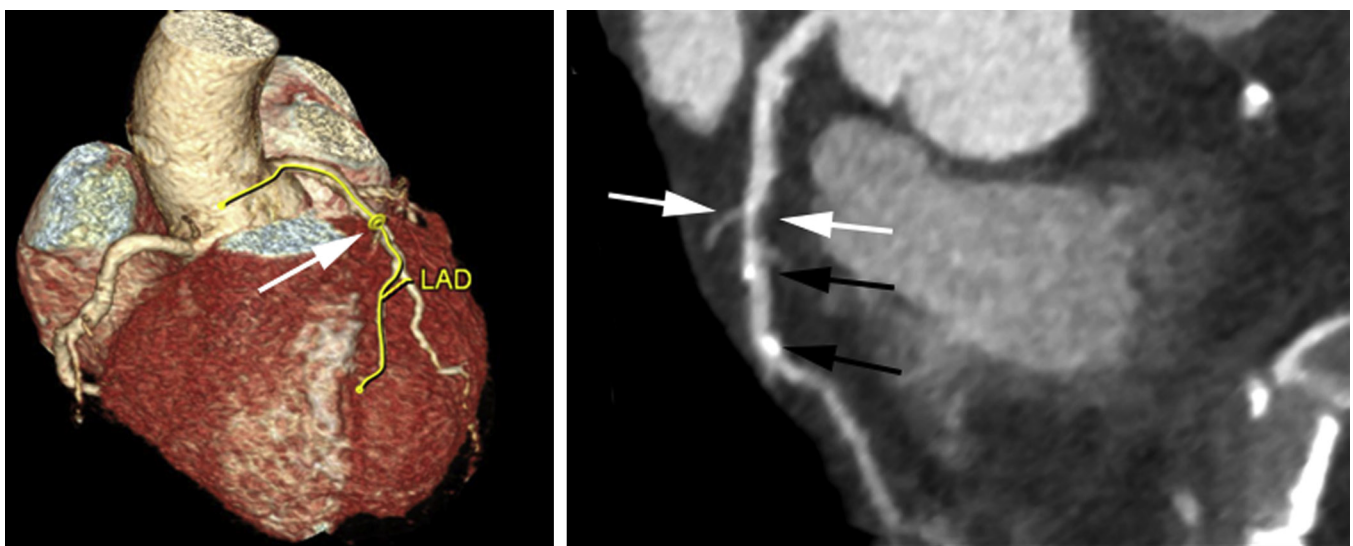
CT-coronary angiogram of a 57-year old GPA patient. A 3D reconstruction of the CT-coronary angiogram demonstrating the location of a significant lesion in the left anterior descending (LAD) coronary artery (left panel, *white arrow*). A 2D reconstruction showing significant stenosis (right panel, *white arrows*) and atherosclerotic plaque (right panel, *black arrows*). Adapted from the personal collection of the authors.
